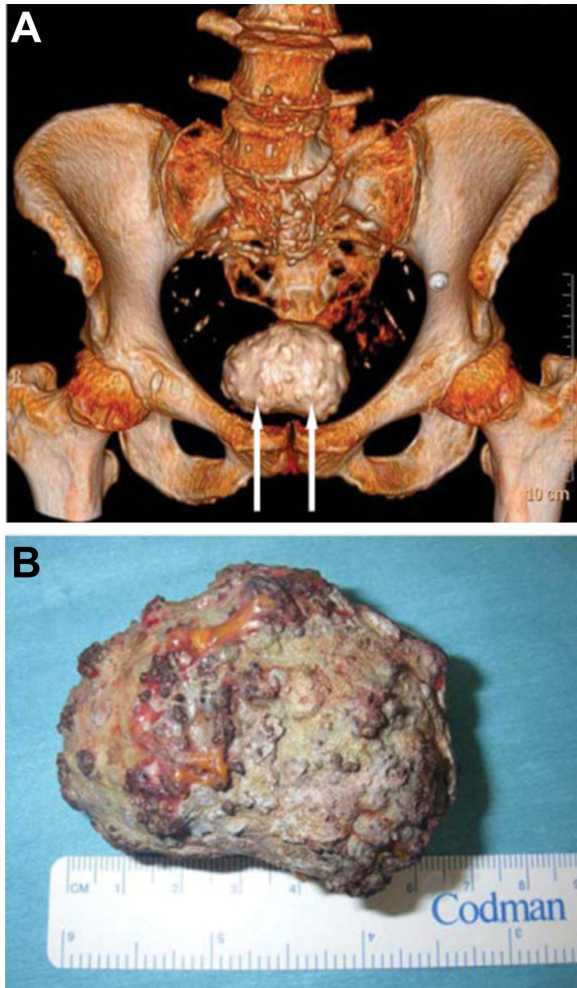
A particularly large urolith. (A) Reconstructed computed tomography image, showing the location and relative size of the urate cystolith (indicated by arrows). (B) Photograph of the urate cystolith, showing its absolute size. Reproduced from reference [345](#) with permission.
